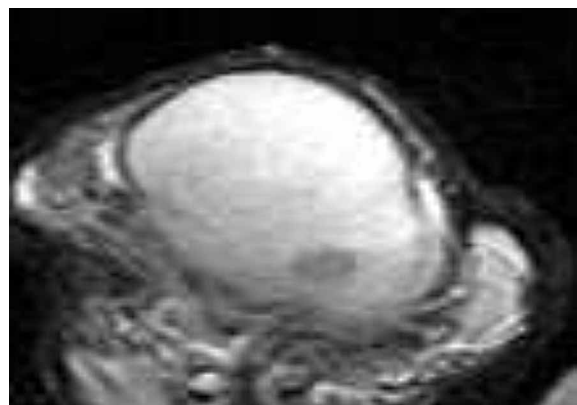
MRI imaging of the right testis obtained two years after left-sided orchiectomy. 1.5 Tesla MRI machine (Philips). T2-weighted image. Notice the small intratesticular mass with low signal intensity. This image corresponds exactly to the sonographic view. Intraoperatively, this mass was missed.
